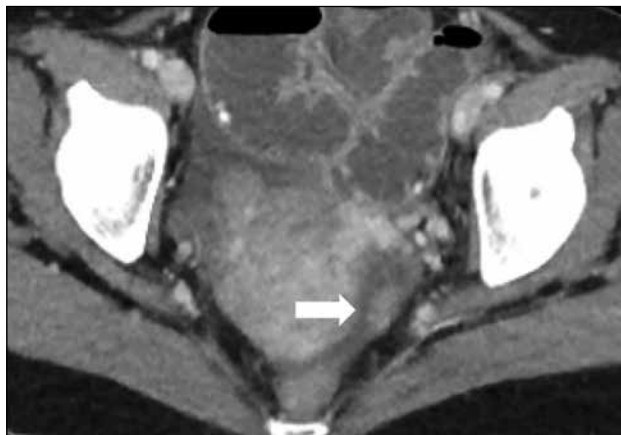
Computed tomography showing a suspected small peritoneal metastasis (arrow).
